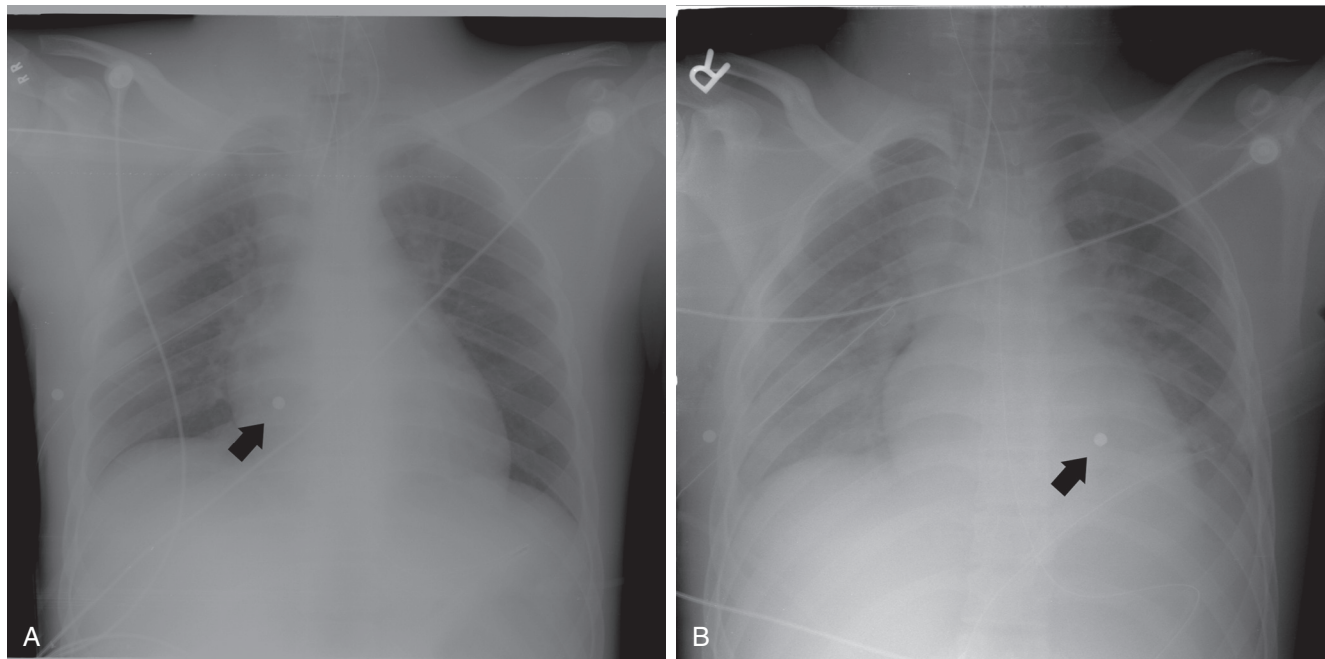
■ A, A patient with multiple fragmentation injuries underwent a complete trauma evaluation and was found to have a ball bearing in the region of the right heart (*arrow*). Pericardial FAST was negative for fluid and he had indications for a trauma laparotomy. B, Postoperatively, the patient underwent a follow-up chest x-ray, which demonstrated that the ball bearing had migrated (*arrow*). A follow-up computed tomography scan demonstrated that the fragment was likely in the pericardium. Consequently, the patient underwent exploration through a median sternotomy and was found to have a small laceration of the right ventricle, which was repaired primarily. FAST, Focused assessment with sonography for trauma.
